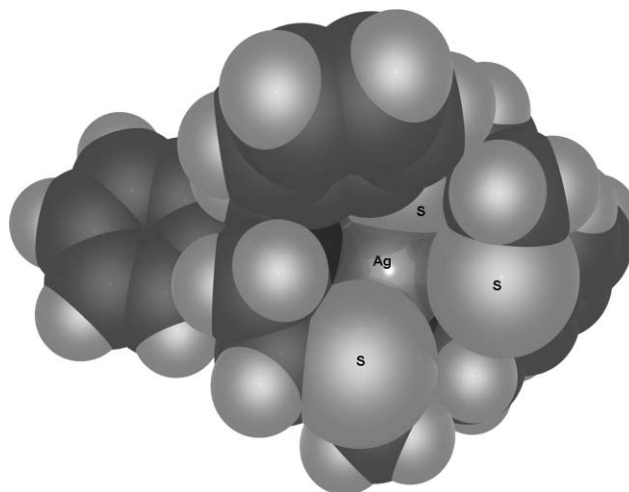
A space-filling depiction of the X-ray structure of the complex cation in [Ag2]PF₆·MeCN.
